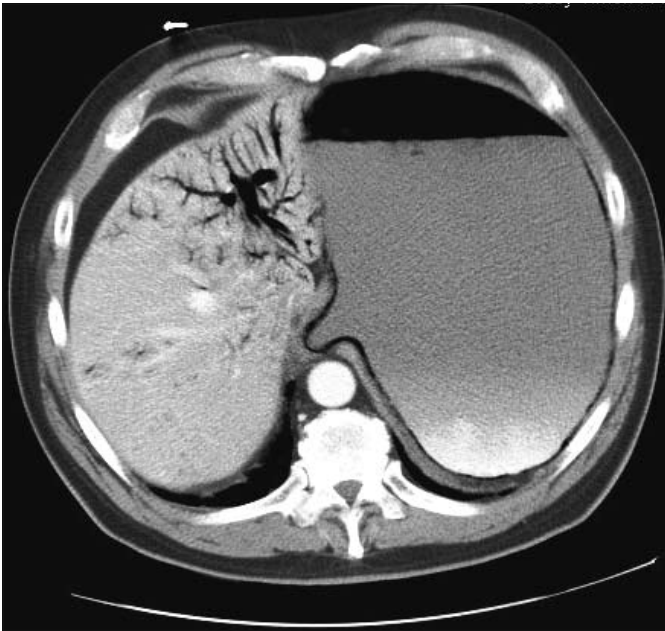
CT image with gastric dilation and portal venous air.
